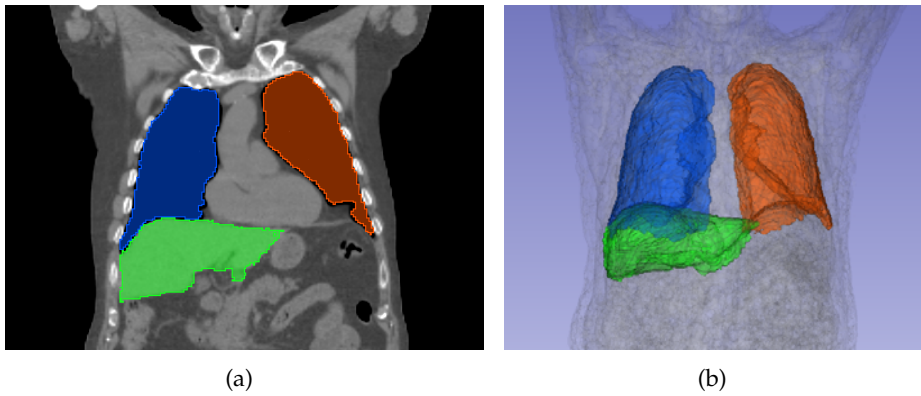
Liver (green), right lung (blue) and left lung (orange) VOIs segmentations, reported on a coronal view superimposed to the CT (a) and in a 3D representation (b).
